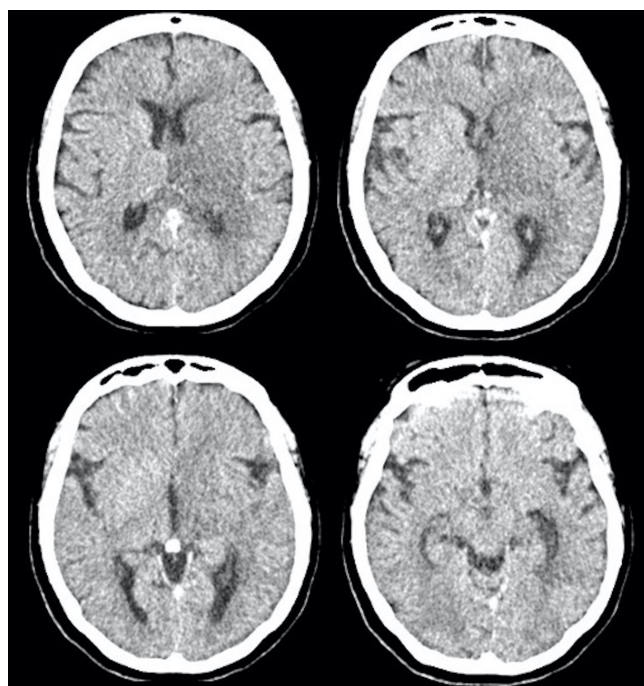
Non-contrast head CT shows left deep hemispheric hypodensity involving the basal ganglia, thalamus, internal capsule and the deep white matter. Hyperdensity of the proximal internal cerebral veins and vein of Galen, without acute signs of hemorrhagic transformation.
